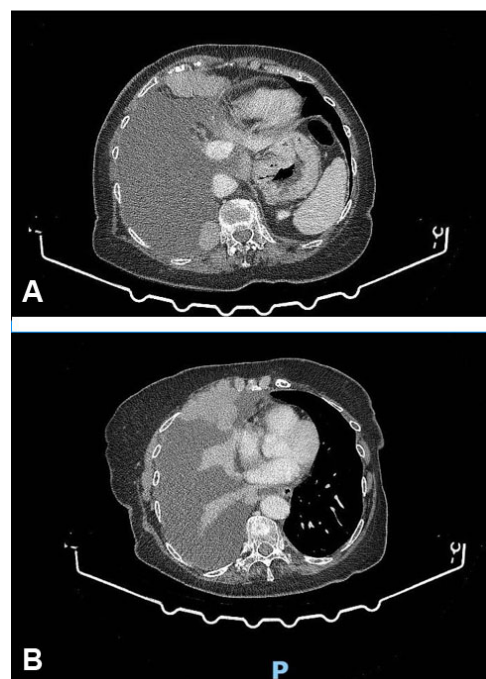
(A and B) CT scan slices showing large pleural masses with pleural effusion.
